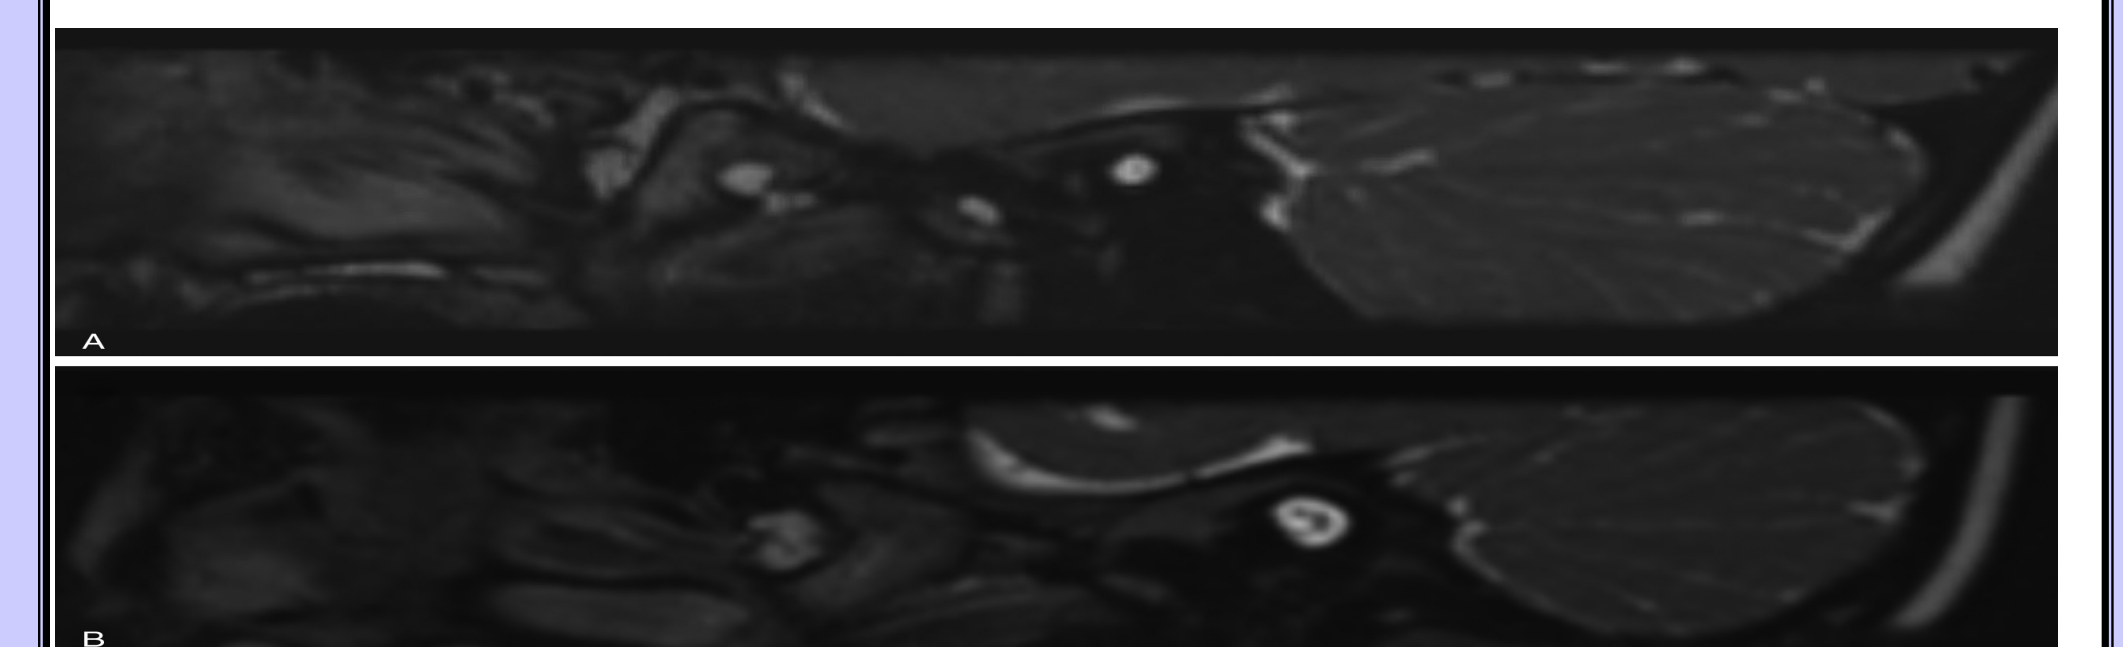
MRI of subject #6 with cochlear nerve aplasia showing one nerve inside left IAC (A) and MRI of subject #2 with cochlear nerve hypoplasia showing only two nerves inside left IAC (B). MRI indicates magnetic resonance imaging; IAC, internal auditory canal.
